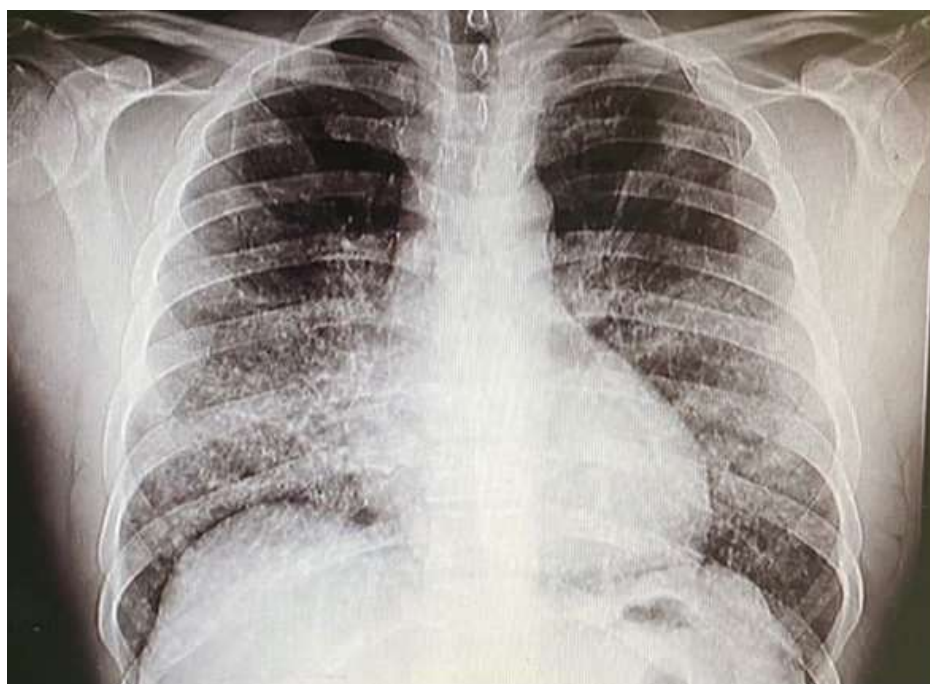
Patient's chest radiograph showing bilateral alveolar opacities
